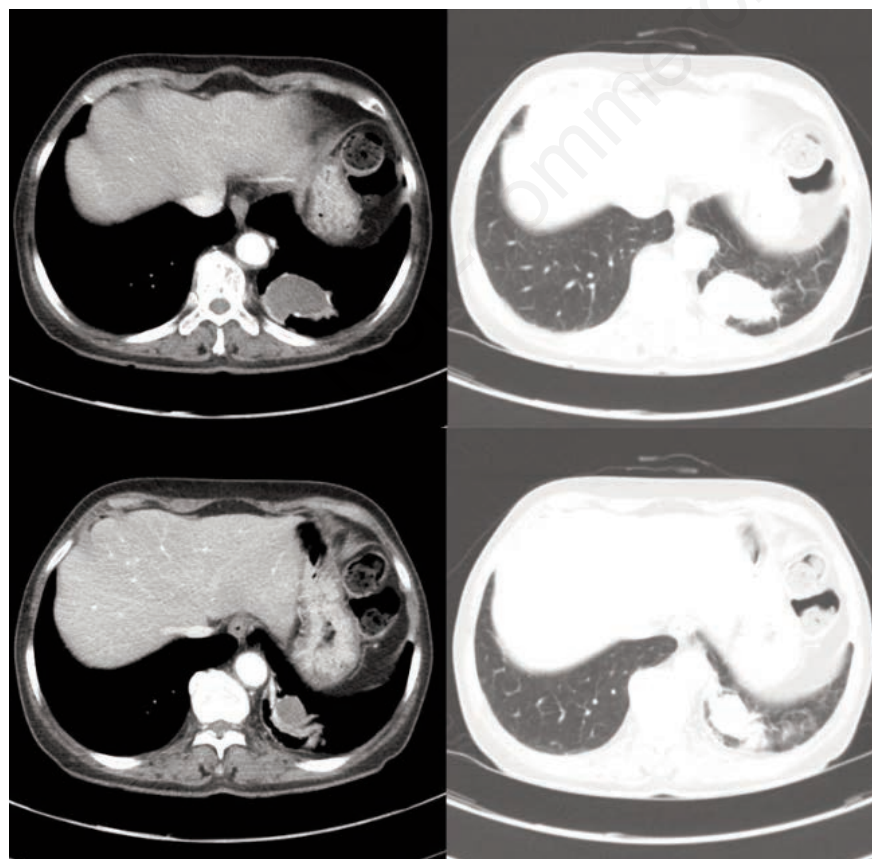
Follow-up CT scan taken in February 2019 shows increased low density lesion.
